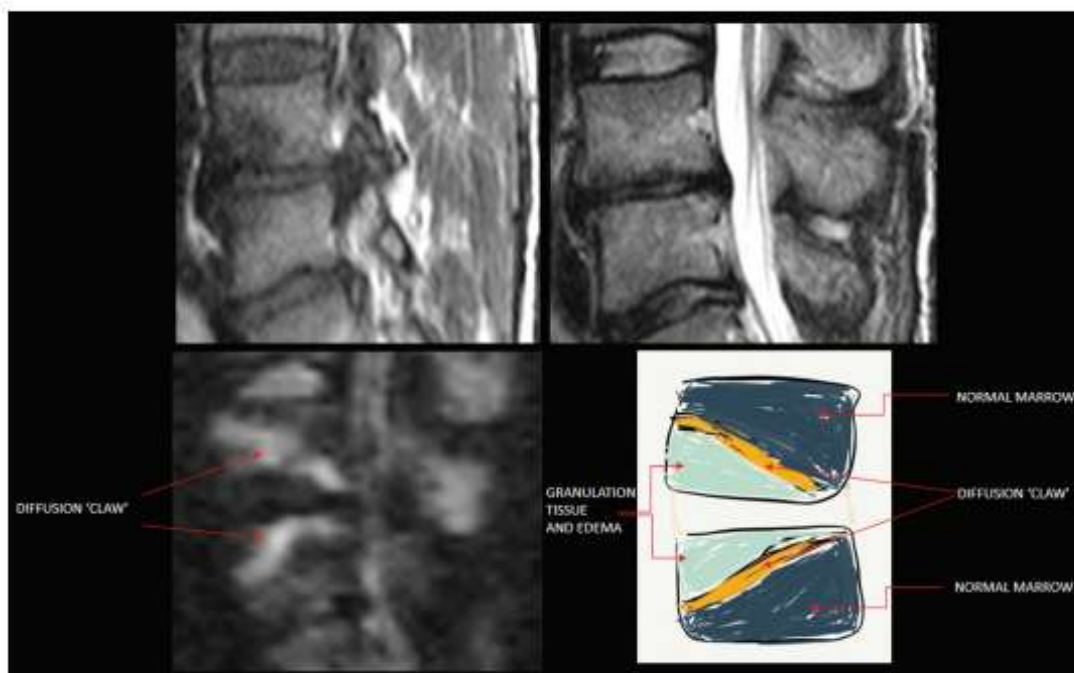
The claw sign is identified on trace/combined DWI as well-margined, linear, typically paired regions of high signal situated within adjoined vertebral bodies at the boundaries between normal and vascularized bone marrow [44].
